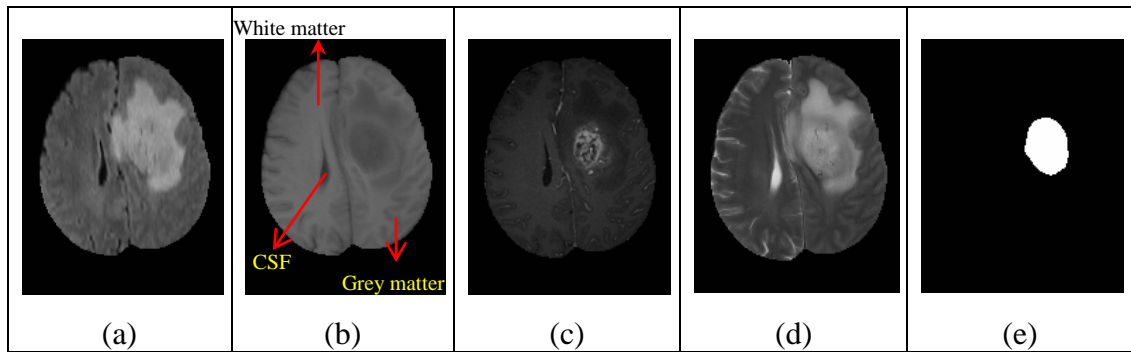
The different sequences of MRI brain tumour image that show white matter, grey matter, cerebrospinal fluid (CSF), and tumour regions in (a) FLAIR, (b) T1, (c) T1-contrast, and (d) T2. Image (e) is the tumour gold standard.
